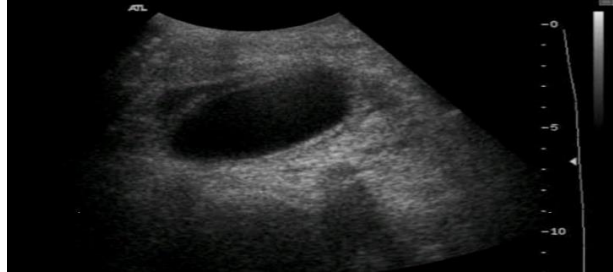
Ultrasound image – a distended, oedematous gall bladder with peri gall bladder collection suggestive of acute cholecystitis.
